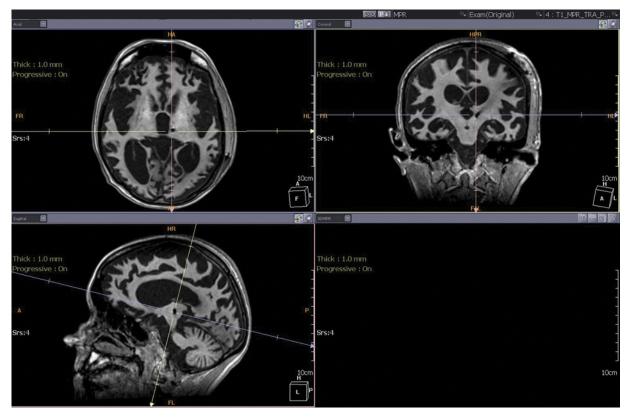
Case 9. Postoperative T1-weighted MR images confirming the position of the electrode in the CM-pf complex. Figure is available in color online only.
